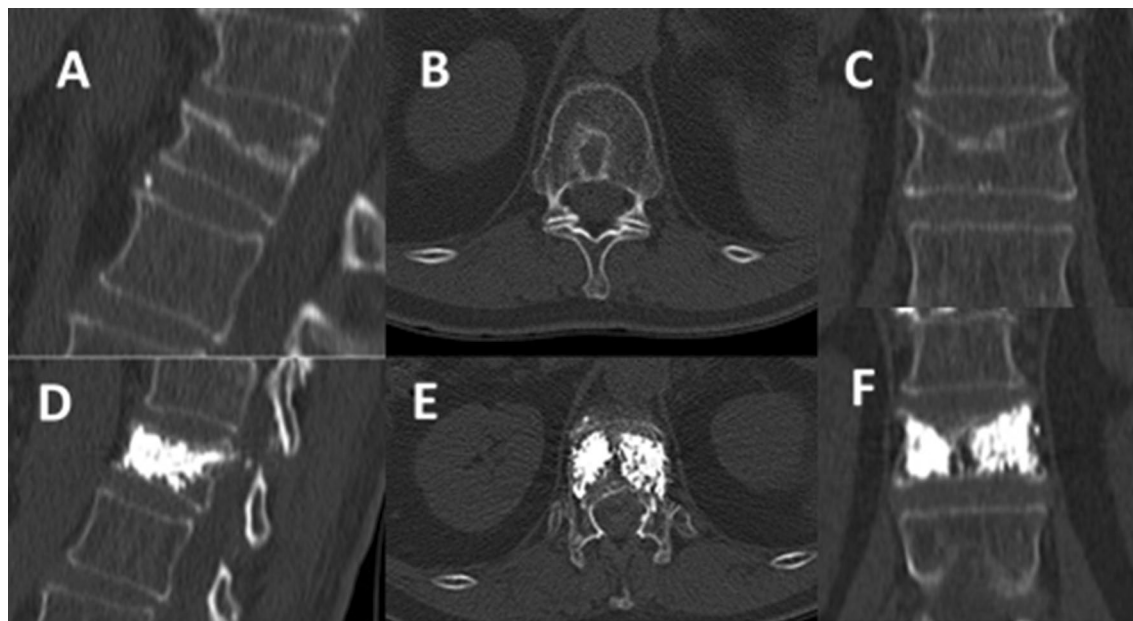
Vertebroplasty of thoracic vertebral fracture (T12), OF type 1. A–C CT scan before surgery (sagittal, axial and coronal), D–F after surgery
